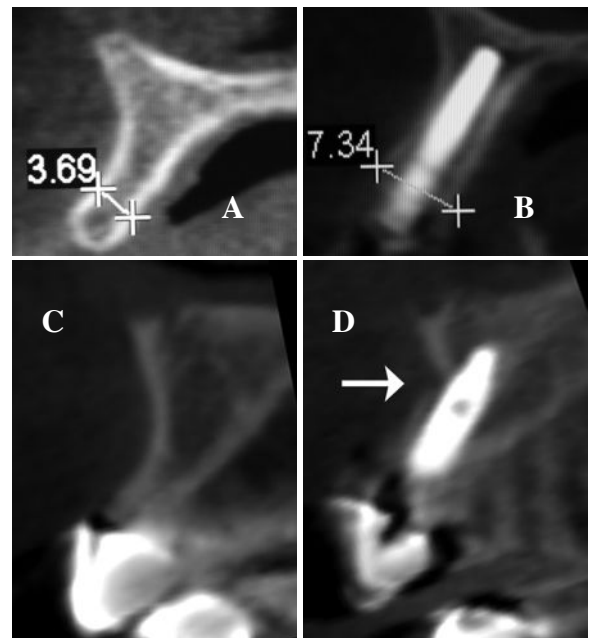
Pre-operative and post-operative CBCT of ridge expansion (RE) demonstrating horizontal dimensional change and fracture. A. Pre-operative and B. Post-operative images of RE demonstrating horizontal dimensional change, C. Pre-operative and D. Post-operative images of RE with severe facial undercut and fracture at the apical one-third of the buccal plate (arrow).
